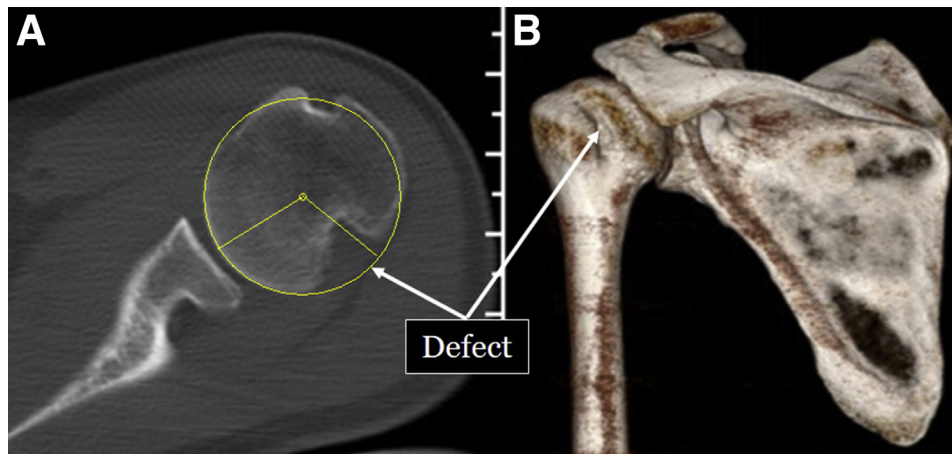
Preoperative computed tomography scans. (A) Cross-section of the left shoulder, showing a Hill-Sachs lesion measuring 14.9 mm in depth. (B) Three-dimensional reconstruction of the humeral head, showing the defect.
